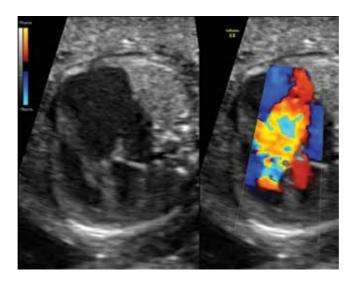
Fetal echocardiogram performed at 22 weeks and 3 days gestation. There is severe enlargement of the right atrium with severe tricuspid valve regurgitation demonstrated on color Doppler evaluation. The tricuspid valve annulus dimension is markedly enlarged.
